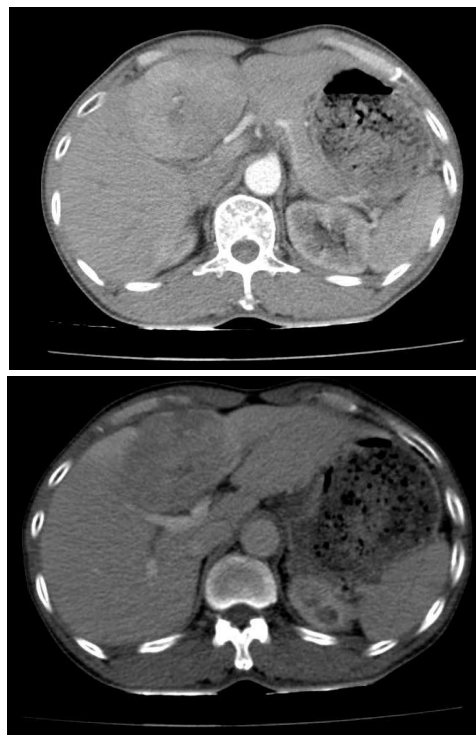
CT scan: Subsegmental mass III and IV measuring 65 × 88 mm, showing arterial phase enhancement and venous washout, with well-defined margins and a distinct capsule, indicative of HCC lesion.
